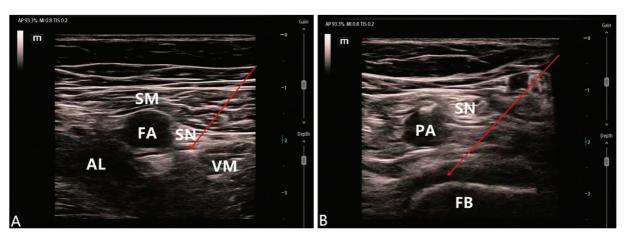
Ultrasound-guided adductor canal block (A) and infiltration between the popliteal artery and capsule of the posterior knee block (B). AL, adductor longus; FA, femoral artery; FB, femoral bone; PA, popliteal artery; SM, sartorius muscle; SN, saphenous nerve; VM, vastus medialis; line, needle insertion point.
